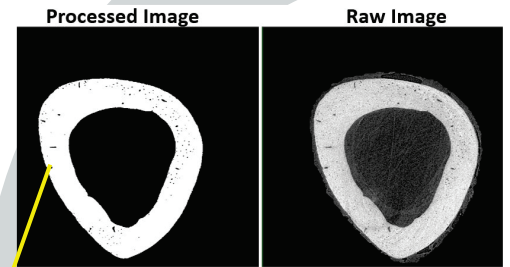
(above). Raw and processed SR- μ CT images. ROIs were created for cortical bone, blood vessels and osteocyte lacunae. Intracortical porosities were then measured. Left. Magnified subregion of the processed image showing blood vessels and osteocyte lacunae.
